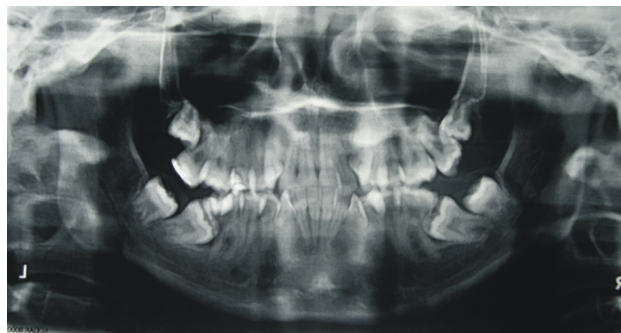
Pretreatment panoramic X-ray.
